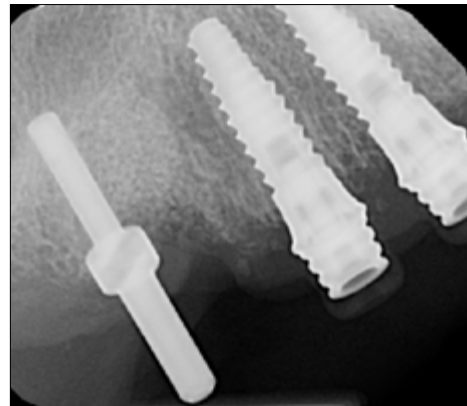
Periapical radiograph showing the alignment pin positioning.
